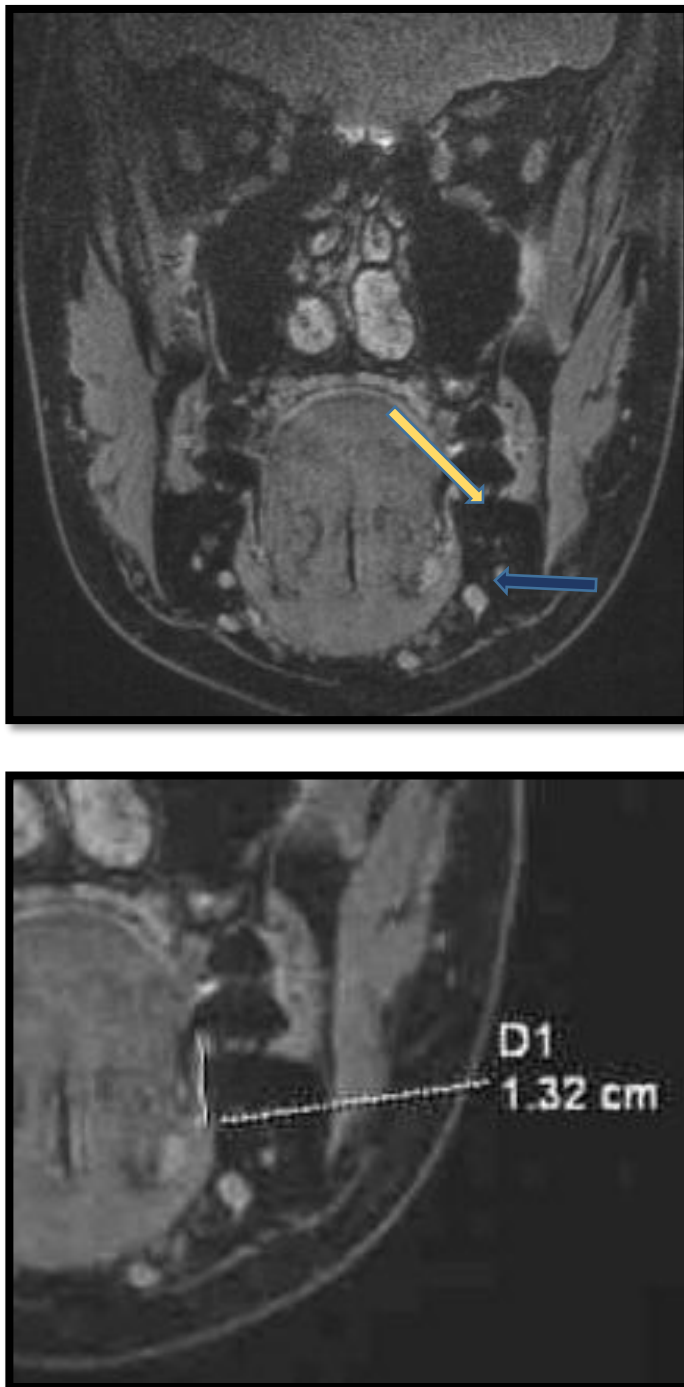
6 MRI coronal view of T2 3D-DESS WE at the level of an erupted third molar region, (point B) notice the intra-oral separator (yellow arrows) and the identified lingual nerve on the right side at point B (blue arrow) this was measured to be 1.32 cm (13 MM).
